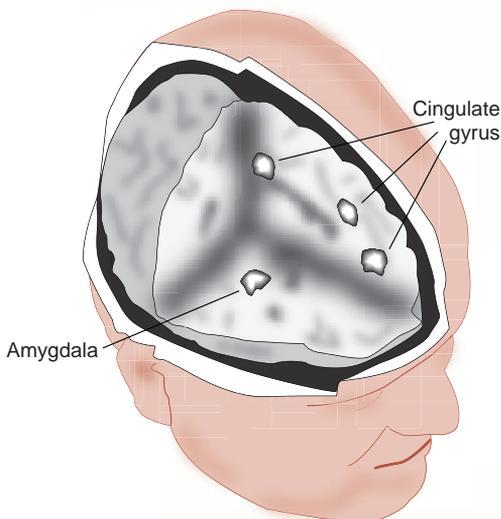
• Criminal psychopaths showed less activity in the amygdala along with parts of the cingulate gyrus when recalling negative affective words compared with controls. (Adapted from Kiehl KA, Smith AM, Hare RD, et al. Limbic abnormalities in affective processing by criminal psychopaths as revealed by functional magnetic resonance imaging. *Biol Psychiatry*. 2001;50:677-684.)
